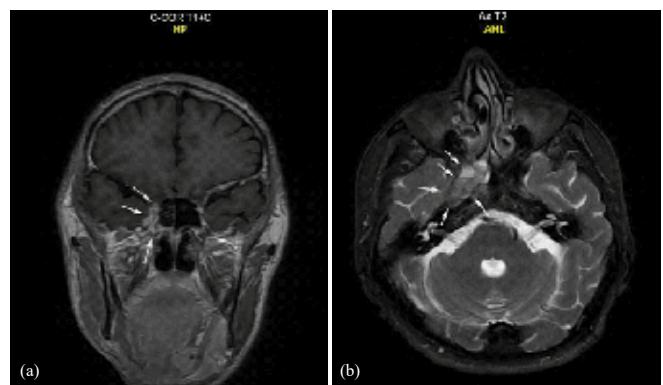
(a) Gadolinium cranial MRI T1 coronal section shows contrast enhancing mass within the right cavernous sinus (marked with white arrows). (b) T2 axial section shows a mass surrounding the internal carotid artery from the anterior and resulting in the thickening of the right temporal dura.
